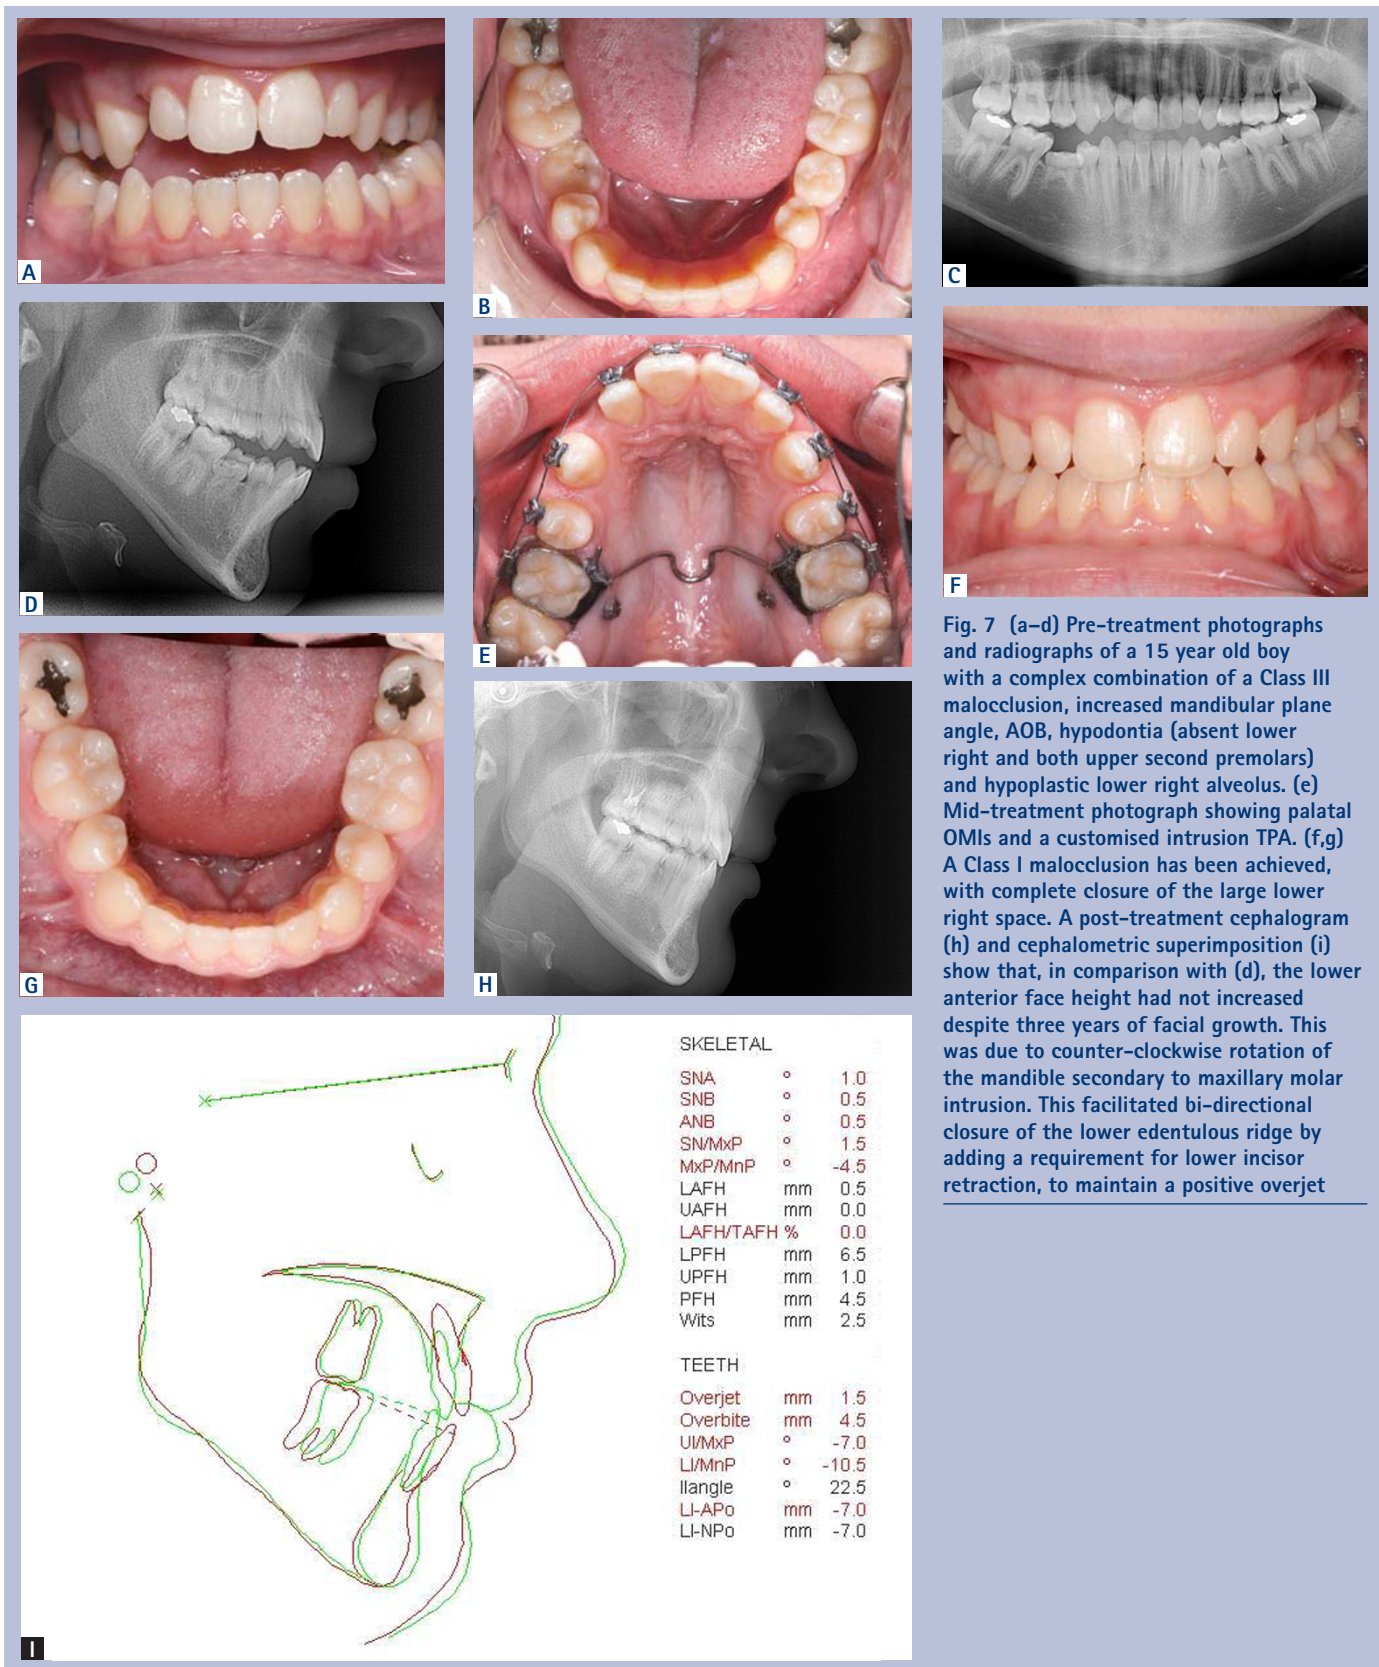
(a-d) Pre-treatment photographs and radiographs of a 15 year old boy with a complex combination of a Class III malocclusion, increased mandibular plane angle, AOB, hypodontia (absent lower right and both upper second premolars) and hypoplastic lower right alveolus. (e) Mid-treatment photograph showing palatal OMI and a customised intrusion TPA. (f,g) A Class I malocclusion has been achieved, with complete closure of the large lower right space. A post-treatment cephalogram (h) and cephalometric superimposition (i) show that, in comparison with (d), the lower anterior face height had not increased despite three years of facial growth. This was due to counter-clockwise rotation of the mandible secondary to maxillary molar intrusion. This facilitated bi-directional closure of the lower edentulous ridge by adding a requirement for lower incisor retraction, to maintain a positive overjet
